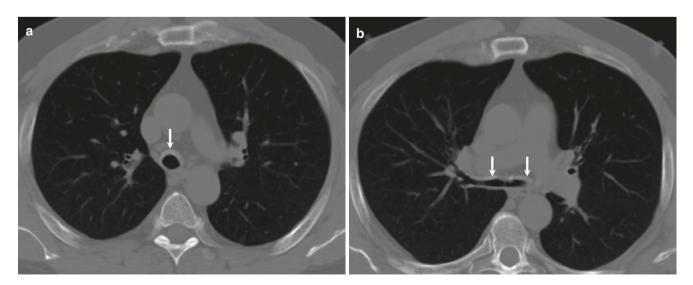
A 55-year-old man with relapsing polychondritis. (a, b) Axial CT images show thickening and narrowing of the trachea and main bronchi with calcification involving the anterior cartilaginous portion of major airways
